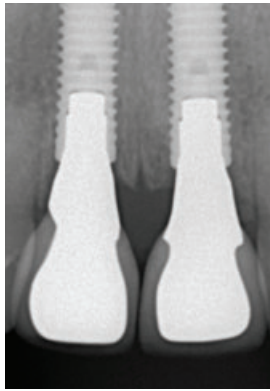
Radiograph of the connected crowns to verify the positive seat of the crossfit connection.
